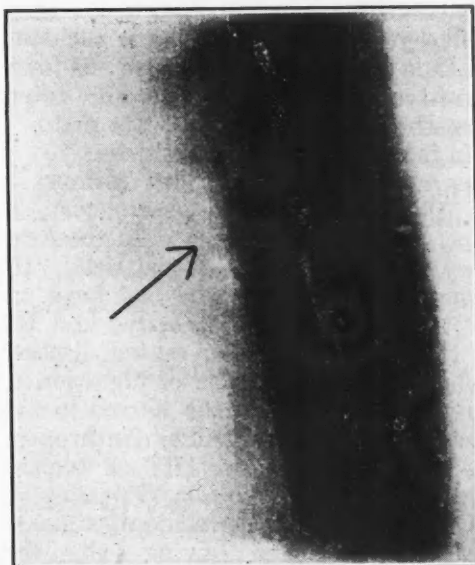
Reproduction (reduced) of x-ray photograph in *Montreal Medical Journal*, March, 1896.
